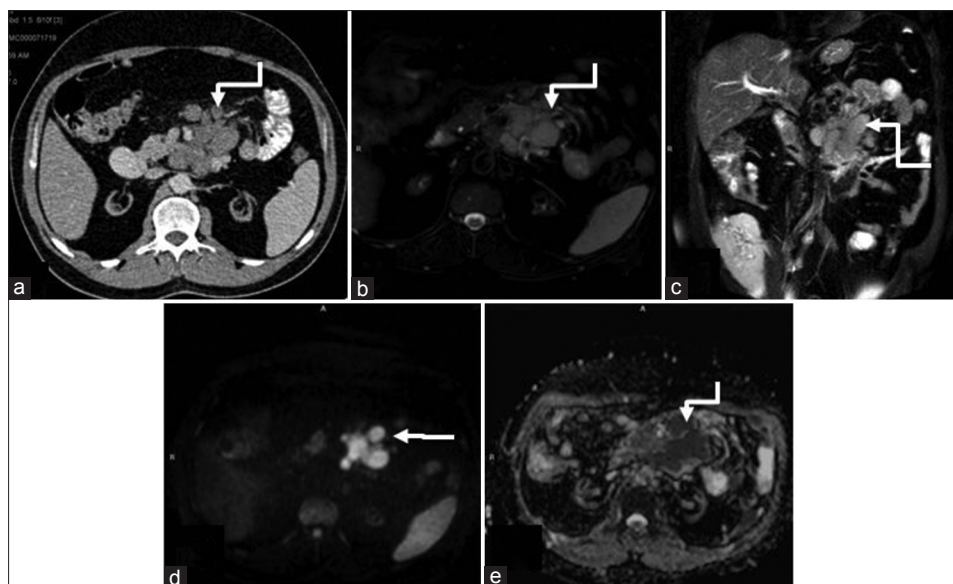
(a) Contrast enhanced computed tomography abdomen showing homogeneously hypodense conglomerate and discrete circumscribed lesions (arrow) in mesentery and peripancreatic locations. Axial (b) and coronal. (c) T2-weighted fat suppressed images showing mild T2 hyperintensity (arrow) with restricted diffusion on DWI (d) and ADC hypointensity (e)
